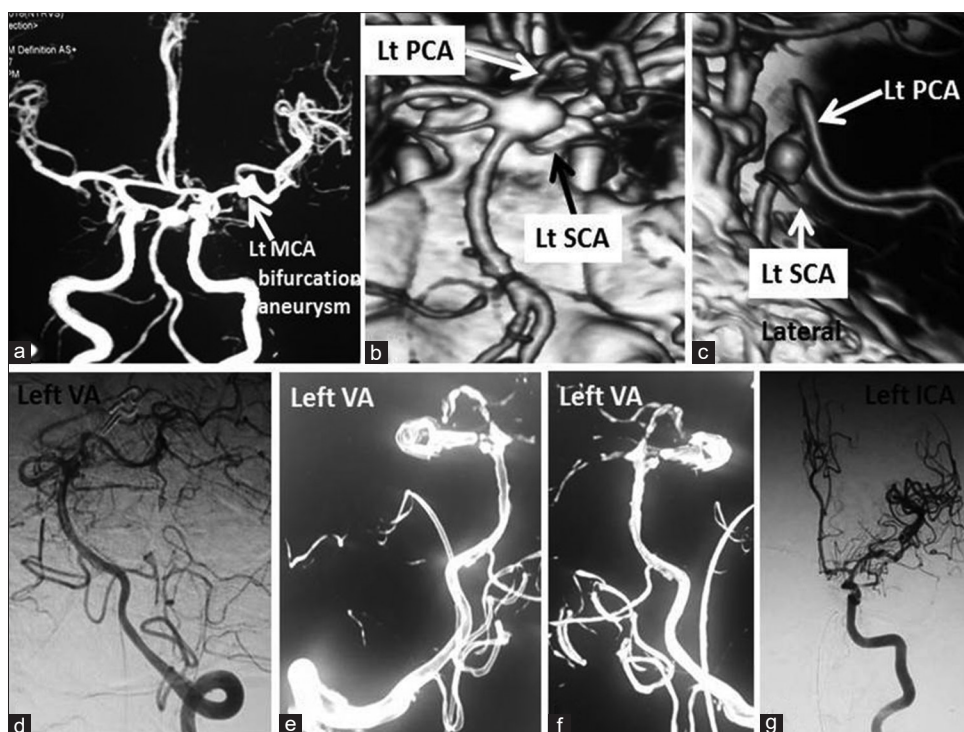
(a-c) Preoperative computed tomography angiogram showing distal basilar trunk aneurysm arising between the origin of the left posterior cerebral and the left superior cerebellar arteries, ectatic dilatation of distal basilar trunk between the origin of superior cerebellar arteries and posterior cerebral arteries, bilobed left middle cerebral artery bifurcation aneurysm (arrow in A). (d-g) Postoperative digital subtraction angiography (DSA) showing successful clip ligation of distal basilar trunk and middle cerebral artery bifurcation aneurysms
